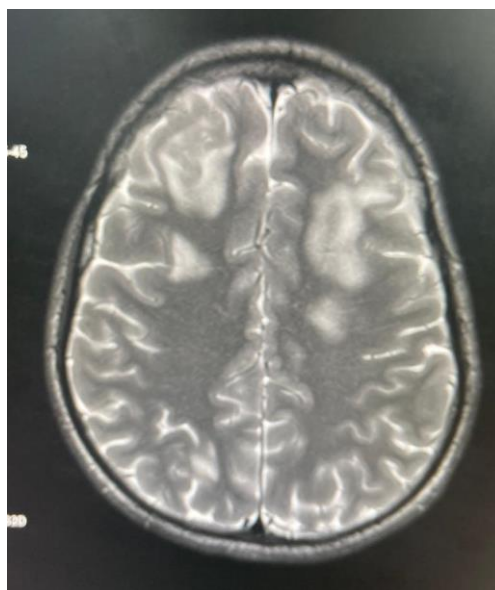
Magnetic resonance imaging depicting posterior reversible encephalopathy syndrome (PRES)
